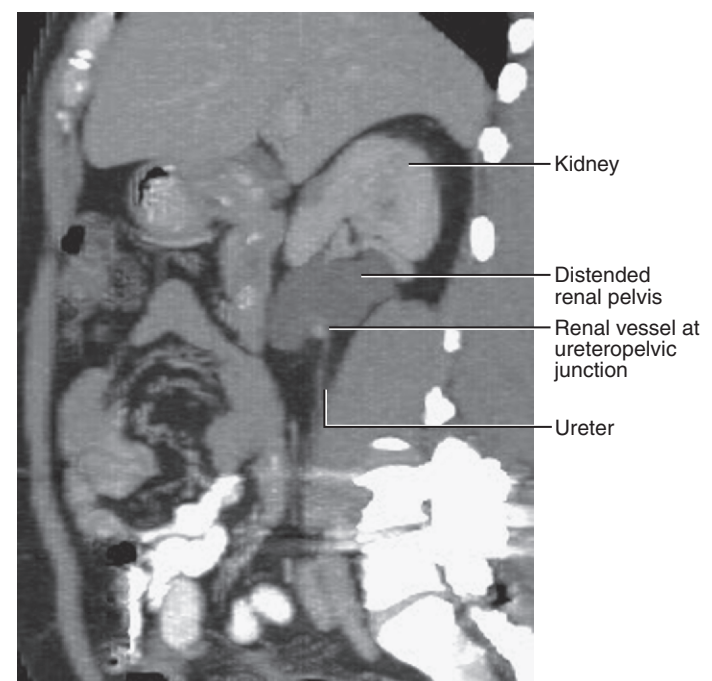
Congenital ureteropelvic junction obstruction. Sagittal reconstruction image of contrast-enhanced computed tomography. This radiologic image shows a blood vessel adjacent to the ureteropelvic junction. It is a matter of debate whether such vessels contribute significantly to the obstructive process. (Image courtesy of Raj Paspulati, MD.)
